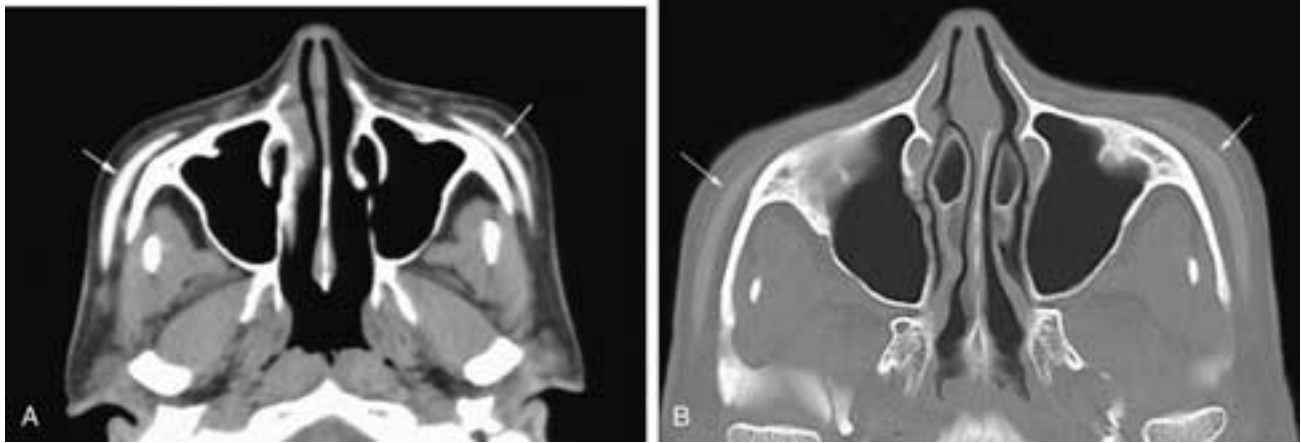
Axial CT scans at narrow (A) and wide (B) window settings on a patient who has had alloplast sheet (arrows) augmentations in her cheeks.
